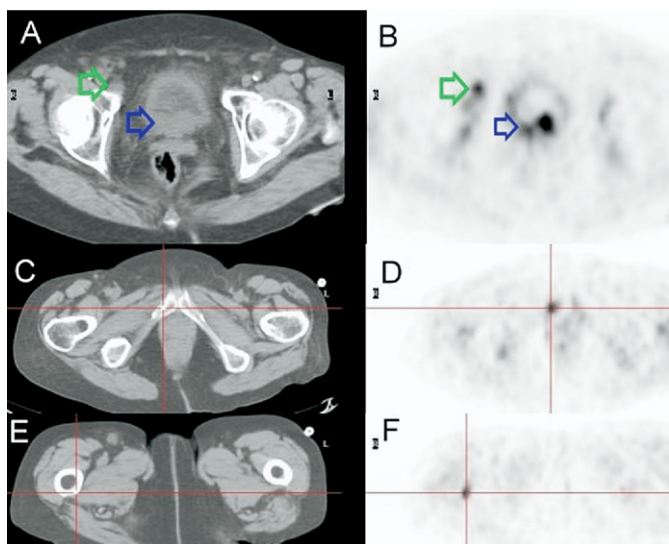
Case 5. A and B, CT and PET views at level of bladder. Primary tumor (blue arrow) and suspicious lymph node (green arrow) are seen. C to F, CT and PET views at level of pubis and femurs. Bone metastases are visualized only on PET (crosshairs) while CT is normal.
